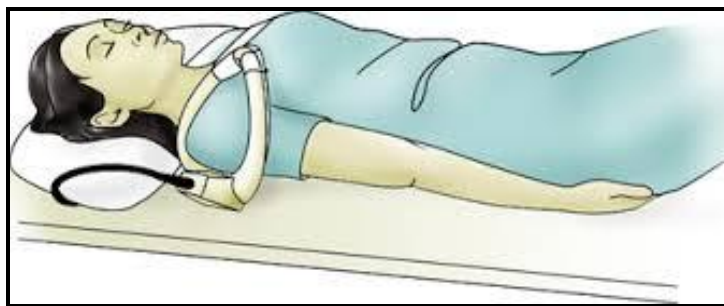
Patient position and single loop coil for MRI shoulder (*Bergin and Schweitzer, 2003*).
